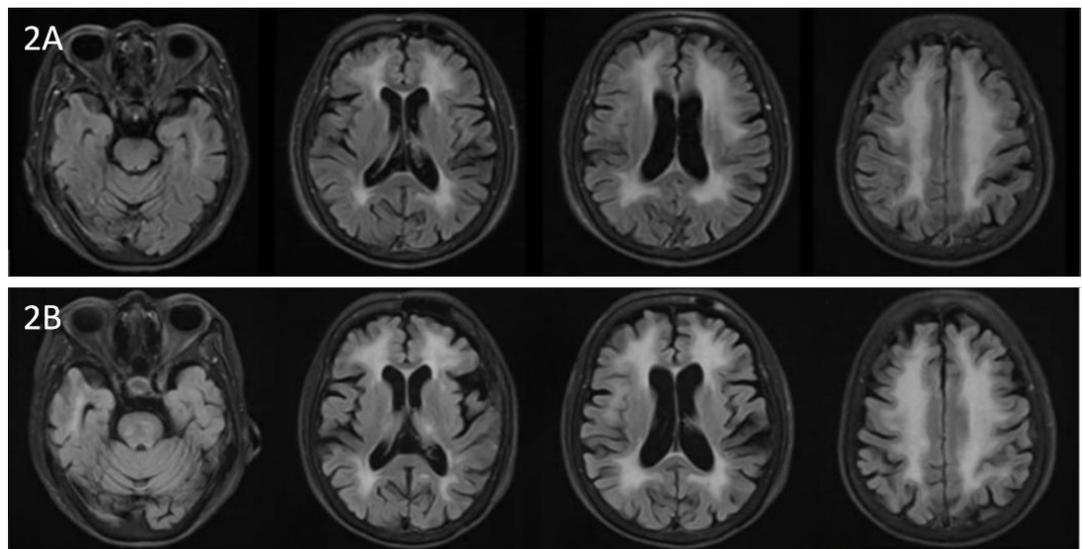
Progressive white matter lesions on T2-FLAIR sequences. (A) Baseline scan (2023) demonstrating confluent periventricular hyperintensities. (B) Follow-up scan (2024) revealing mildly increased extent and confluence of patchy periventricular hyperintensity, consistent with disease progression.
